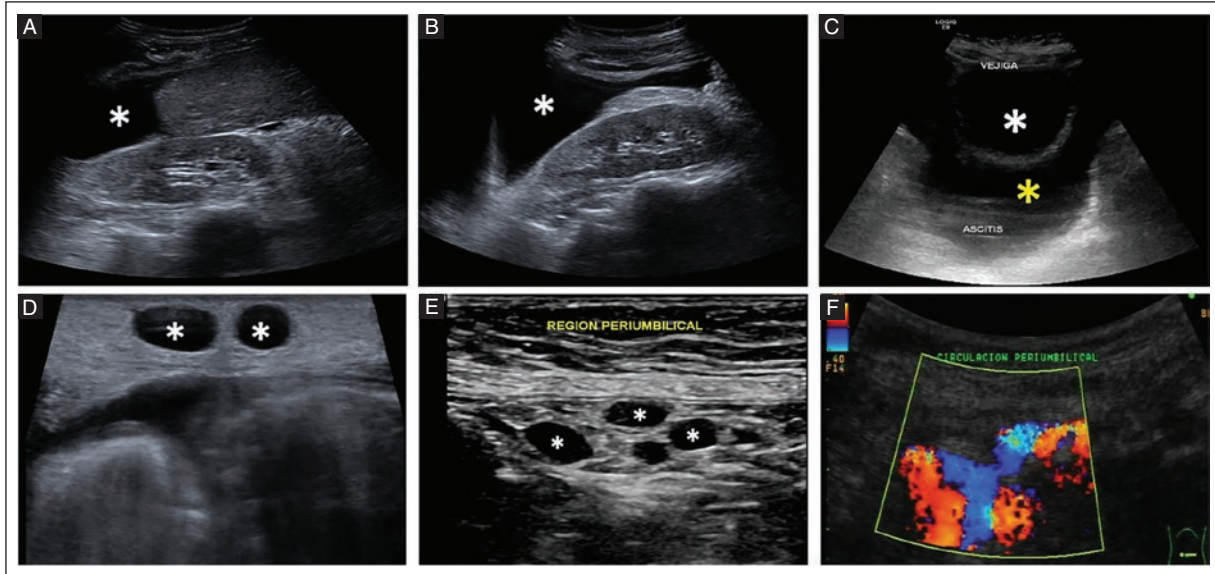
Grayscale US findings of the inframesocolic region in portal hypertension assessment. A and B: a 36-year-old woman with Budd-Chiari syndrome, longitudinal view on grayscale US in the right and left parietocolic gutter with free fluid in both gutters (asterisks). C: a 77-year-old woman with post-necrotic cirrhosis, grayscale US, transverse view showing the bladder (white asterisk) and abundant free fluid around the bladder (yellow asterisk). A 48-year-old man with alcoholic liver disease. D-E: grayscale US with a high-resolution linear transducer (10 MHz) showing multiple 8 to 10 mm periumbilical dilated vessels (white asterisks) in relation to the collateral circulation. F: color Doppler US with sectorial transducer (6 MHz) showing multiple dilated periumbilical vessels in relation to the collateral circulation.
